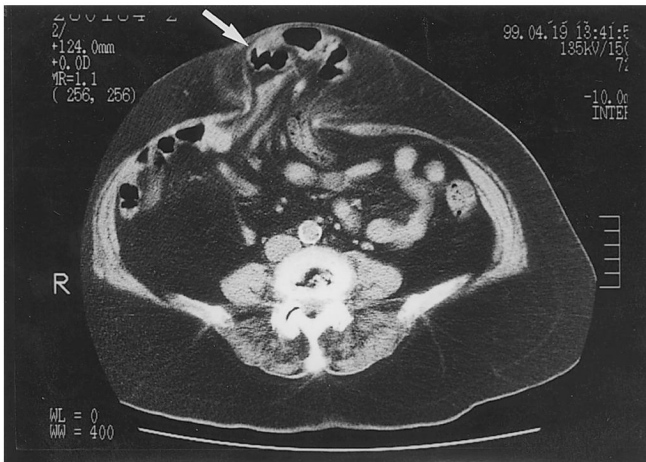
Abdominal CT showing incarceration of bowel and mesentery into the sac of umbilical hernia (arrow).
